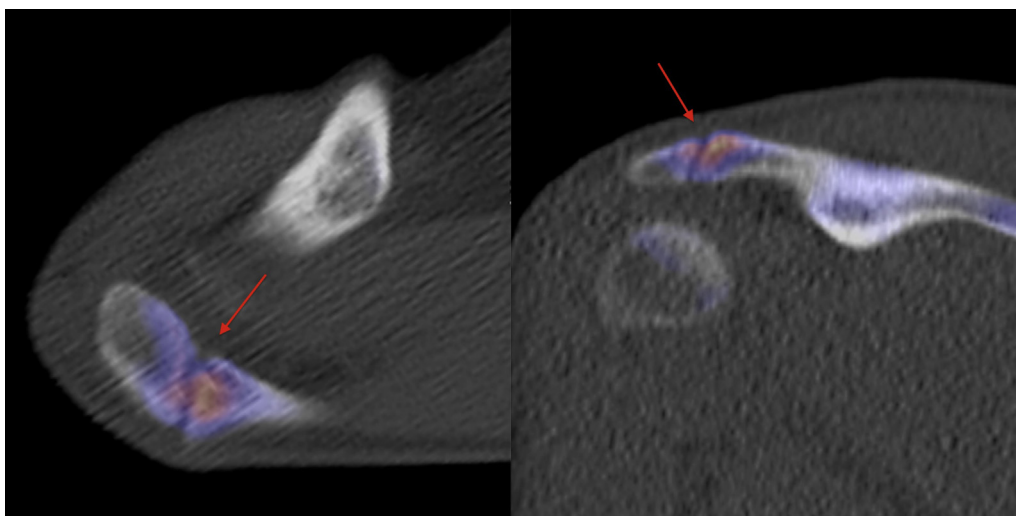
SPECT/CT axial (left) and coronal (right) reveals increased activity at the unfused mesoacromion, indicating ongoing osteoblastic activity likely from a painful os acromiale. SPECT, single-photon emission CT; CT, computed tomography.
